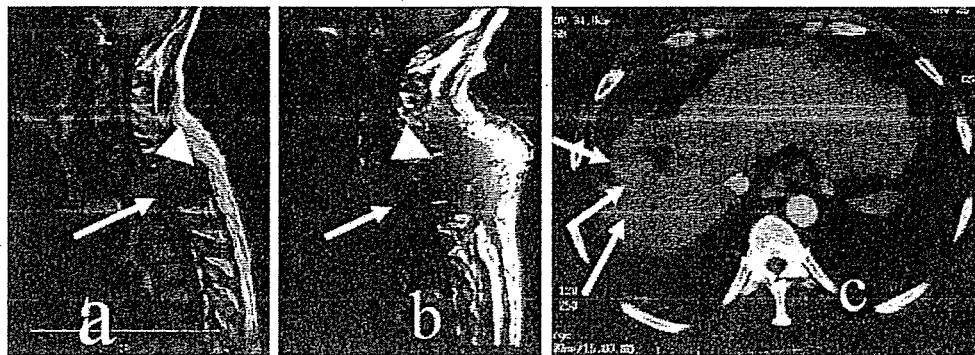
64 year-old male with HCC appeared with tetraplegia. a. MRI showed a vertebral tumor (arrow head) at Th1 pressed upon the spinal cord (arrow). b. Laminectomy decompressed the spine at Th1 (arrow) but the resected area was swollen by edema after the operation (arrow head). c. Computed tomography revealed multiple liver tumors (arrow) suggesting hepatoma after the vertebral operation.
